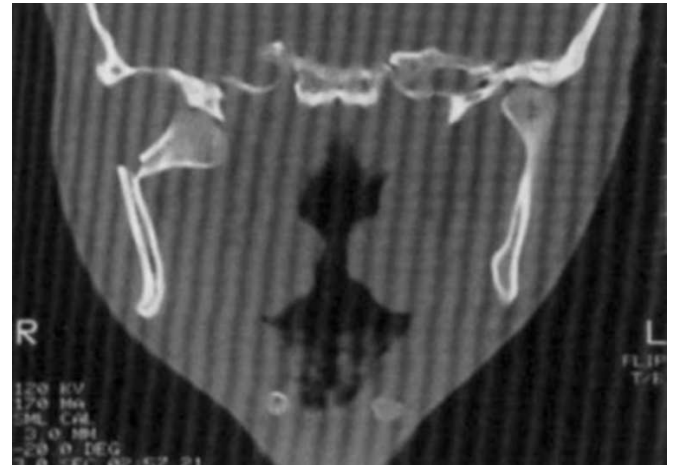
CT image (coronal slice) depicting a medial dislocation of the right mandibular condylar head.
